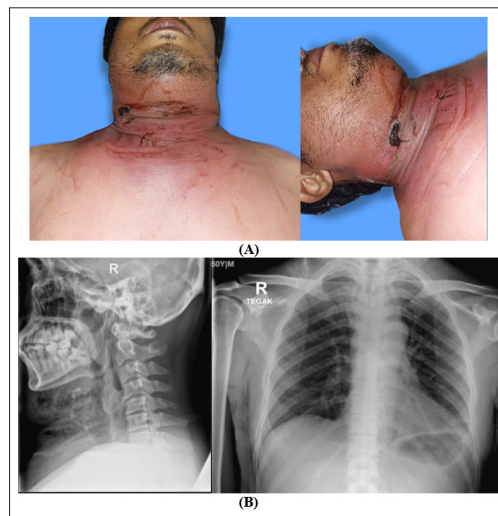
(A) Clinical photograph of the patient showing hyperemia from the submandibular region to the sternum accompanied by pus and blood discharge; (B) AP/lateral cervical X-ray; (C) AP chest X-ray
